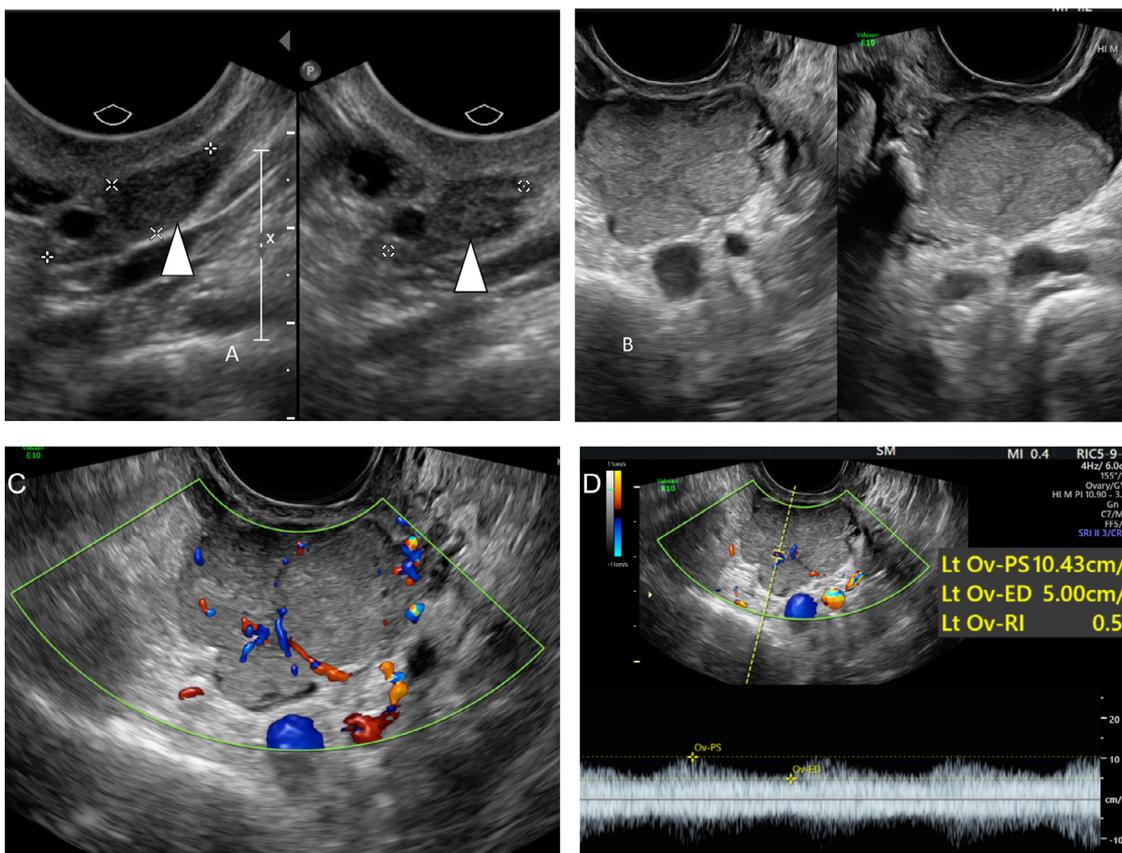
(A) An initial pelvic ultrasound (November 2016) shows a small 1 cm solid mass in a normal-sized ovary (arrow head). (B) A follow-up ultrasound (January 2019) shows a solid mass in the same ovary surrounded by free pelvic fluid. At surgery a malignant serous epithelial tumor was diagnosed. (C and D) Color and spectral Doppler images demonstrating moderate vascularity and a low resistance flow pattern consistent with a malignant ovarian tumor.
